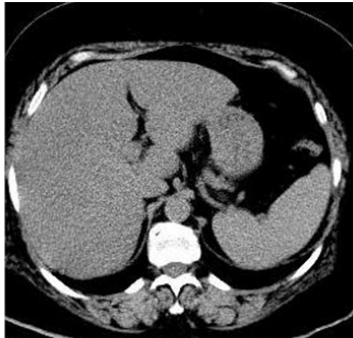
(A): non enhanced CT , mild hepatic steatosis with density = 38 HU. (B) Enhanced CT in arterial phase, the density of the liver is less than the spleen.
